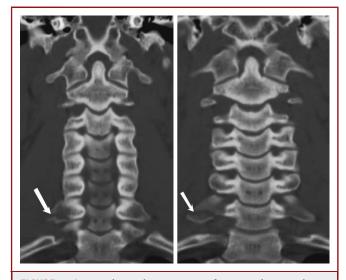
Sequential coronal reconstructions of a computed tomography scan clearly demonstrating right C7 transverse process fracture (arrow).
